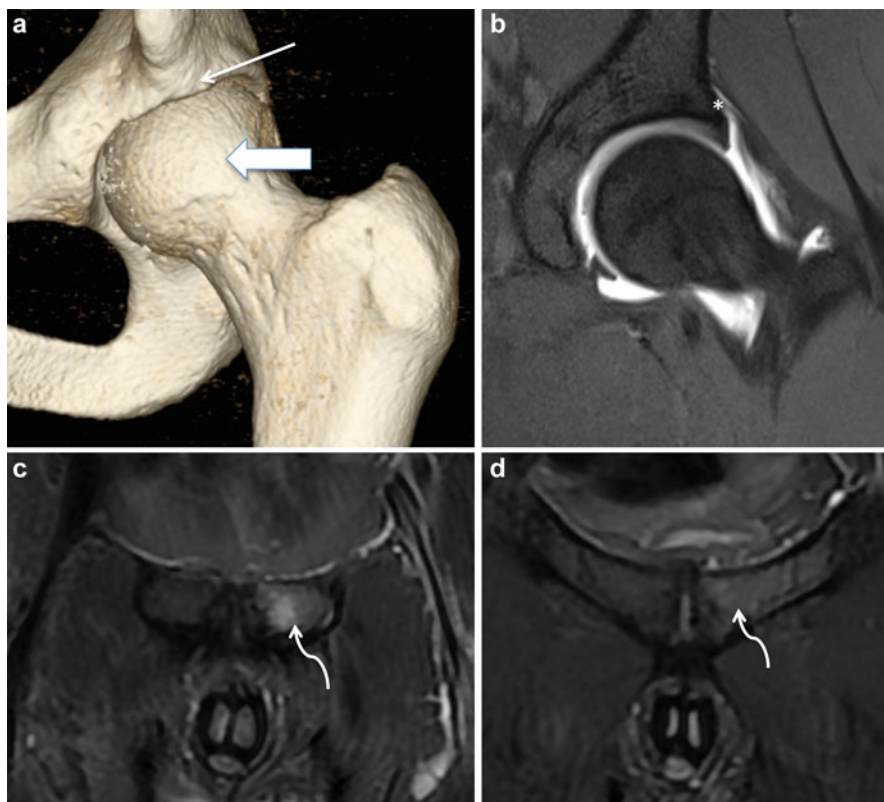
(a) 3D CT reconstructions of the left hip demonstrate focal overcoverage from acetabular retroversion (*thin arrow*) at the anterosuperior aspect of the acetabulum as well as decreased femoral head–neck offset (*thick arrow*). (b) T2 MRA of the left hip demonstrating an intact chondrolabral junction (*). (c and d) T2 MRI sequences of the anterior pelvic ring demonstrating increased signal in the left parasymphseal bone (*curved arrows*)
